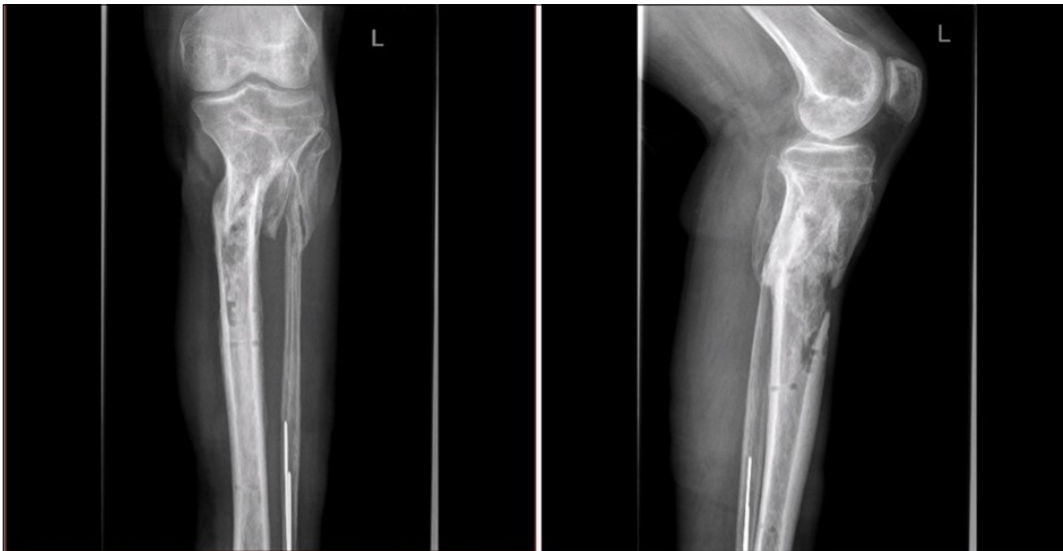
d) 4.8.2016 X-ray
